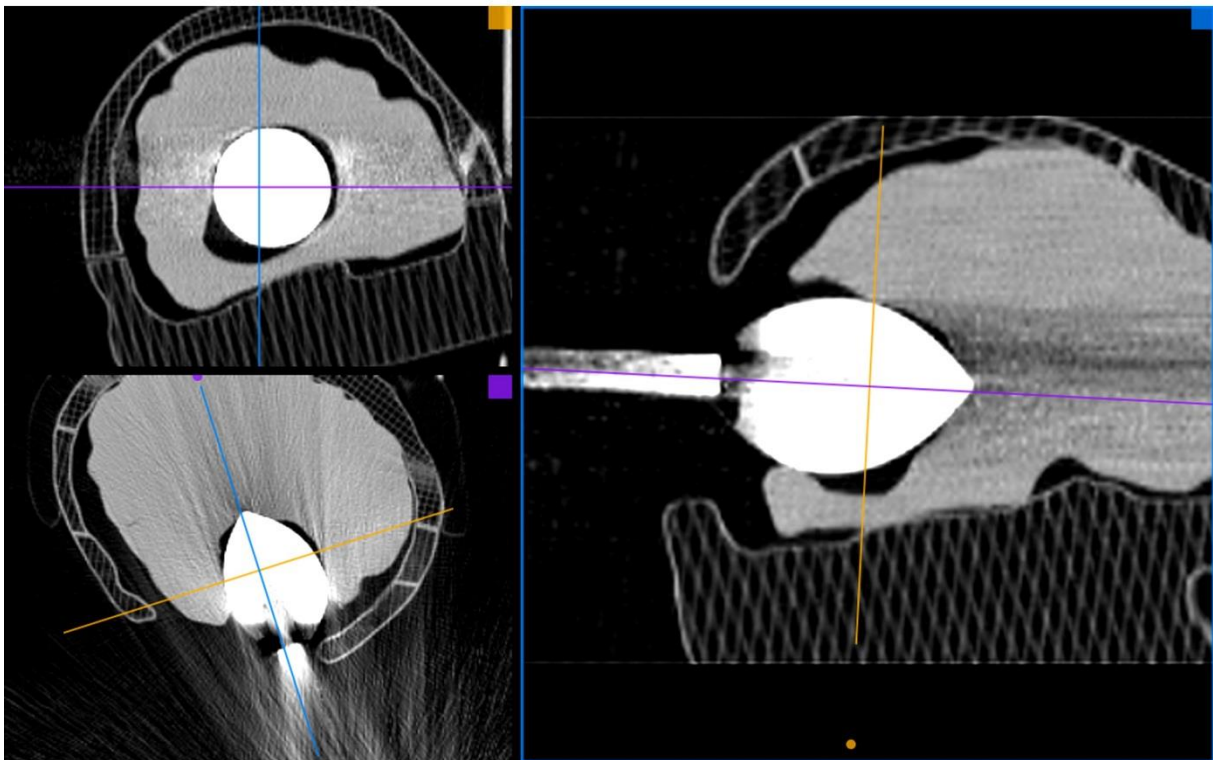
Multiplanar reconstruction of the CT-scan imaging. The balloon was filled with 70 mL of iodine solution.
